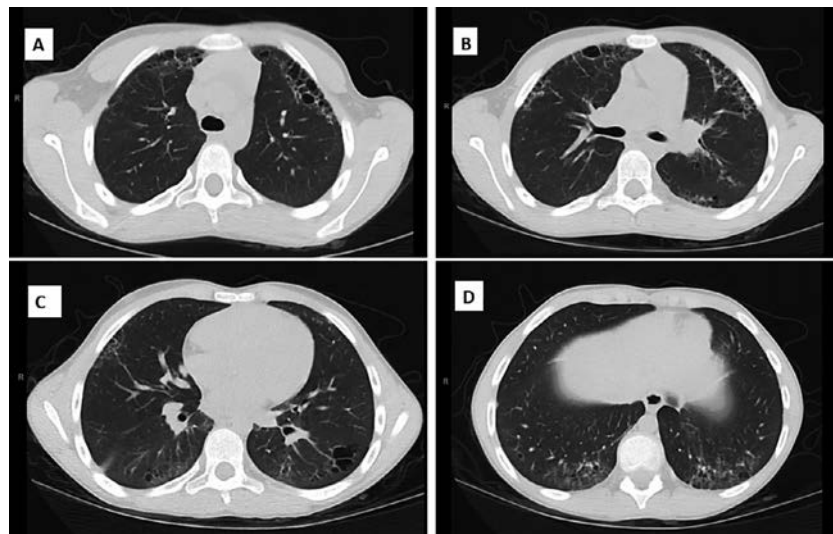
Interstitial lung disease (ILD) in a 9-year-old girl with systemic sclerosis. A–D (cephalad to caudal lungs) demonstrate high-resolution computed tomography (CT) findings consistent with ILD, including peripheral ground-glass opacities, with distribution in all lobes with hyperdensity in the anterior mid (A and B) and lower (C and D) lobes, stacking cystic changes consistent with honeycombing, especially in the anterior upper lobes (A), and subpleural cystic changes in the posterior lower lobes (C and D). Concurrent pulmonary function tests were discordant with the moderate-to-severe degree of pulmonary involvement seen on CT, with a forced vital capacity of 78% predicted, total lung capacity of 96% predicted, and a diffusion capacity for carbon monoxide of 84% predicted. The patient had been treated with cyclophosphamide, hydroxychloroquine, rituximab, glucocorticoids, mycophenolate mofetil, and tocilizumab to help stabilize her ILD, underscoring the severity of her condition.
